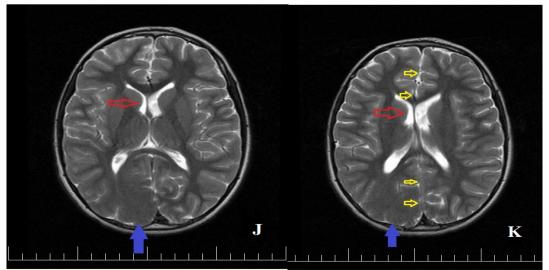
Image J and K. T2-weighted axial MRI of brain showing cortical dysplasia and mild enlargement of the right occipital lobe (blue arrows), asymmetric and dysmorphic right ventricle (red arrows) and mild displacement of the midline of the brain (yellow arrows).
